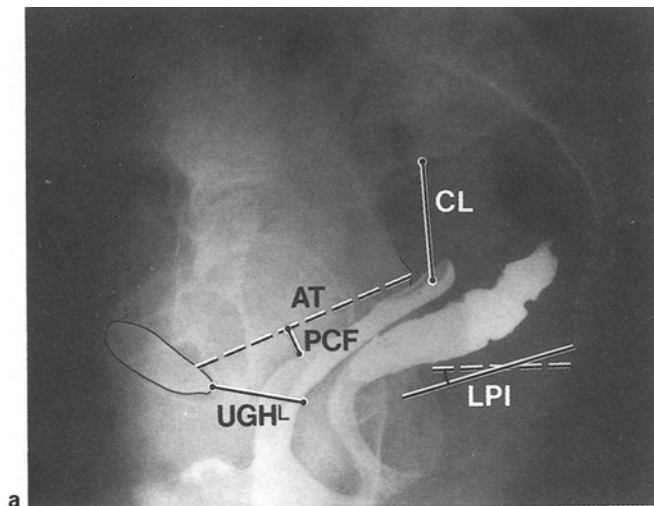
a Frontal radiograph of the pelvis with barium paste in the vagina. NB: A line with a dot at each end indicates the distance spanned by the indicated structure (e.g. CL) while those ending in a single dot point to the structure (e.g. PCM). b Support structures: frontal view. The levator ani has been cut in the coronal plane lateral to the vagina. The shape of the vaginal wall is shown to correspond to its radiographic appearance, showing the impression of the cervix (C) and urethra (U) on the vaginal lumen. Abbreviations used in this and subsequent figures: AT, arcus tendineus fasciae pelvis; C, cervix; CL, cardinal ligament; CO, cervical os; CX, cervix; E, enterocele; ICM, iliococcygeus muscle; LP, levator plate; LPI, levator plate inclination; OI, obturator internus muscle; P, piriformis muscle; PCF, pubocervical fasciae; PCM, pubococcygeus muscle; PDI, pelvic diaphragm (levator ani) inclination; R, rectum; U, urethra; USL, uterosacral ligament; UGD, Urogenital diaphragm; UGH<sup>L</sup>, urogenital hiatus length; UGH<sup>W</sup>, urogenital hiatus width; V, vagina.
